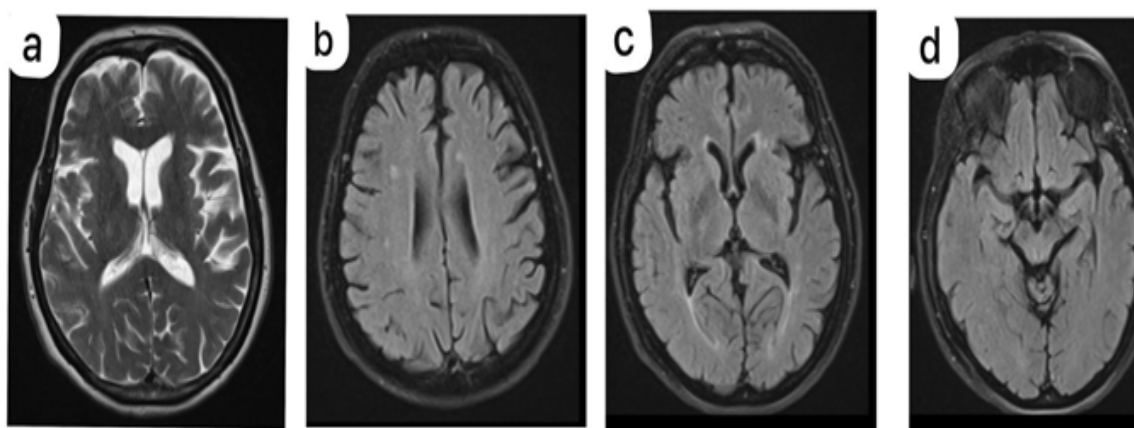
Axial T2 (a) and Fluid-Attenuated Inversion Recovery (b, c, d) MRI images of the brain showing asymmetric cortical atrophy in perirolandic and parietal regions (b).
